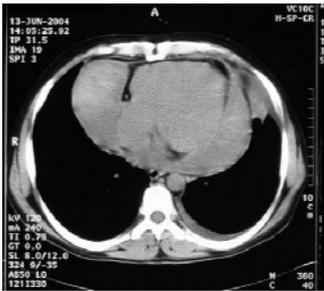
Plain cardiac CT
